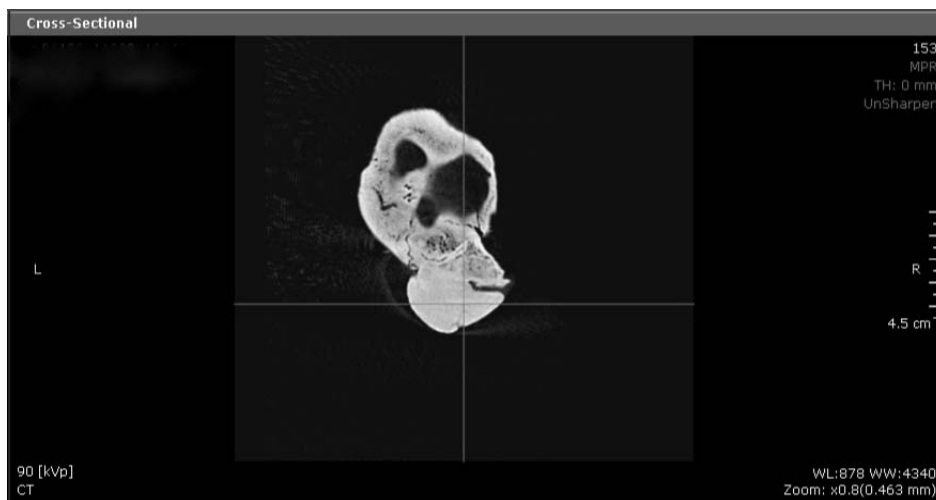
CBCT cross-sectional view of the mastoid osteoma (R12, ♂, 55–60 year-old).
